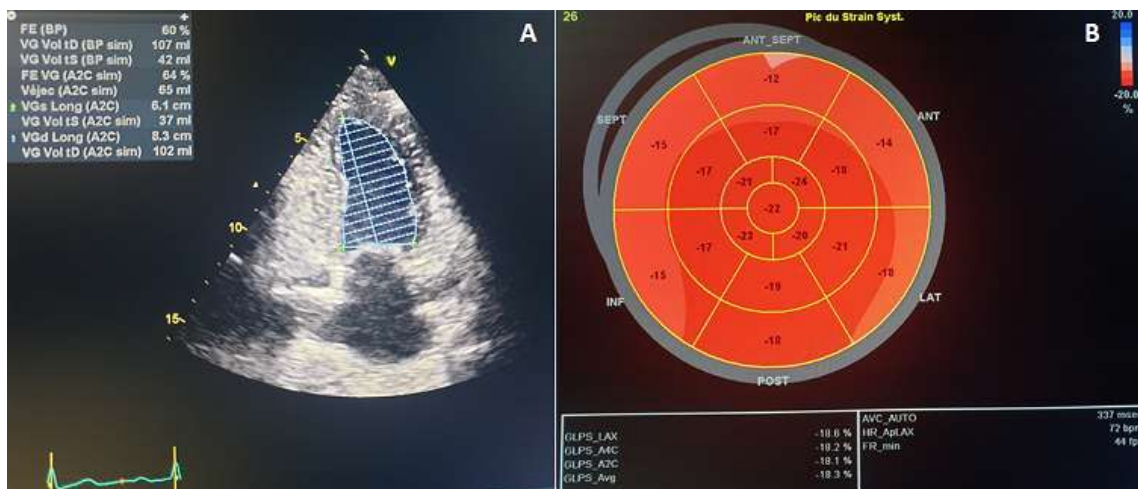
echocardiography showing a left ventricular of normal size and good global and segmental systolic function: A) ejection fraction at 60% with the Biplane Simpson Method; B) global longitudinal strain preserved at -18,3% and segmental strain slightly altered at the bases
